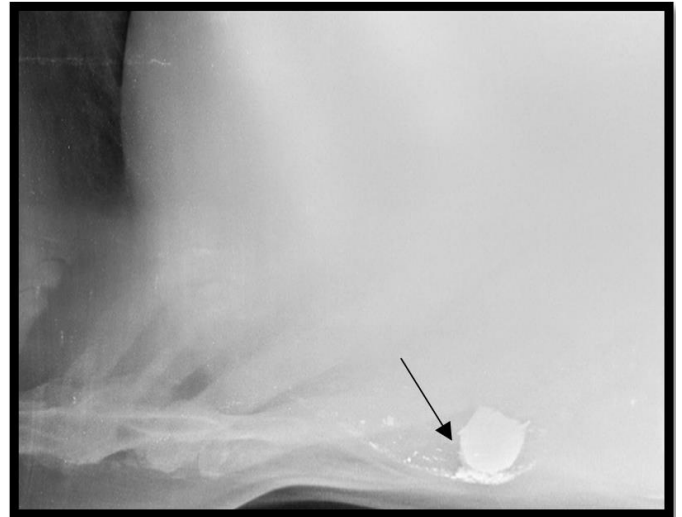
Radiograph showing circular foreign body in reticulum
